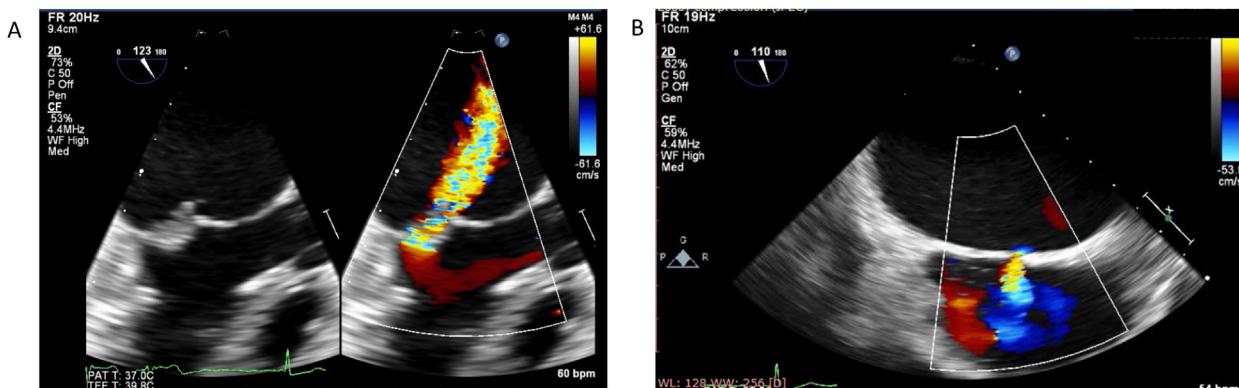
Examples of complications and common findings from PBMV. (A) TEE long-axis view of the MV in 2D and color Doppler post PBMV, demonstrating a complication of leaflet tearing (left) leading to acute mitral regurgitation (right). Note smaller than expected MR jet area related to hypotension and high LA pressure caused by acute severe MR, which may underestimate the severity of MR. (B) Color Doppler of TEE in bicaval view showing left-to-right shunt across the interatrial septum expected from transseptal puncture post PBMV.
